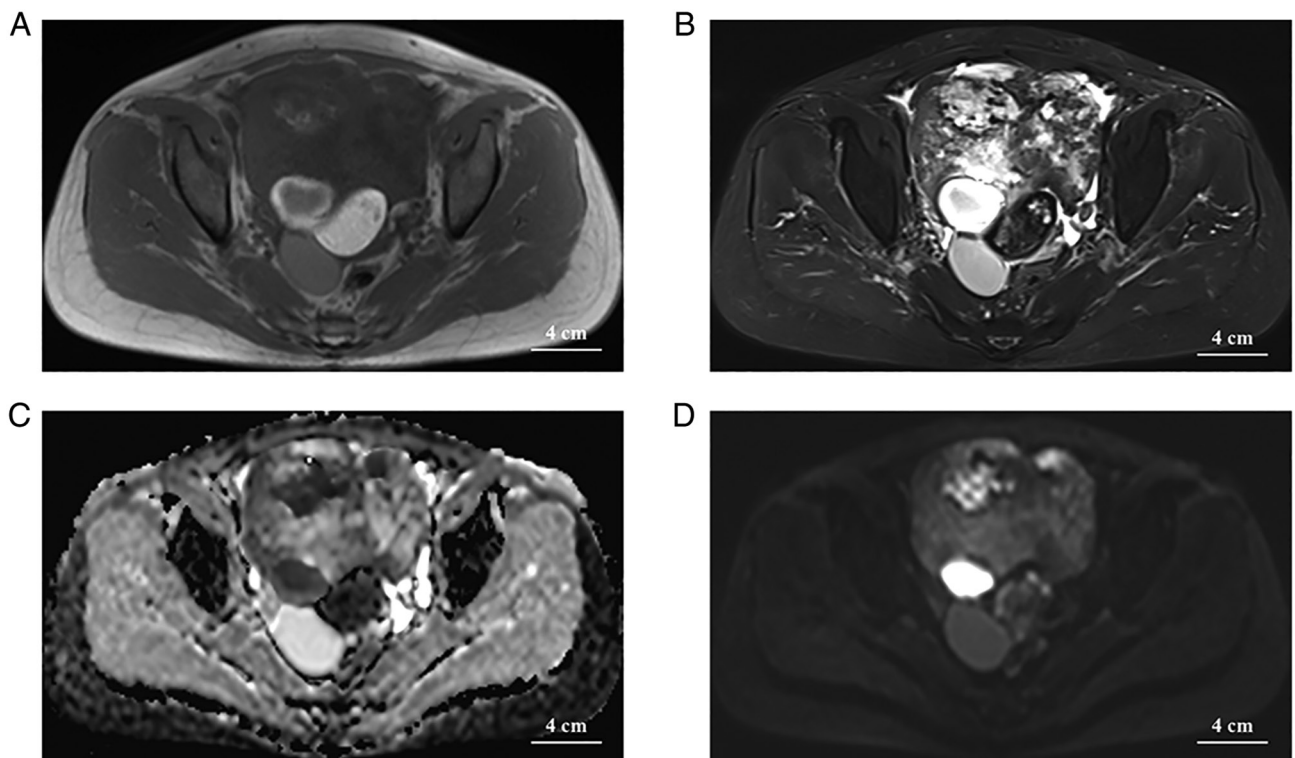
(A) Axial T1-weighted MRI indicating a large mixed-signal lesion in the pelvis with a small lobulated solid cystic mass in the right posterior region, which is surrounded by a large anterior mass forming a 'nested tumor' pattern containing fatty nodules (arrow) with well-defined margins. (B) On the axial fat-suppressed T2-weighted image, the larger anterior portion of the entire occupying lesion displays with a mixed signal with a predominantly hypersignal, while the posterior portion of the fat nodule has a distinct hyposignal. (C) In the ADC image, the mass is predominantly hypersignal with a lamellar hyposignal. (D) The portion of the ADC image that is hyposignal appears as a slight hypersignal on DWI ($b=1,000 \text{ sec/mm}^2$) (scale bar, 4 cm).
